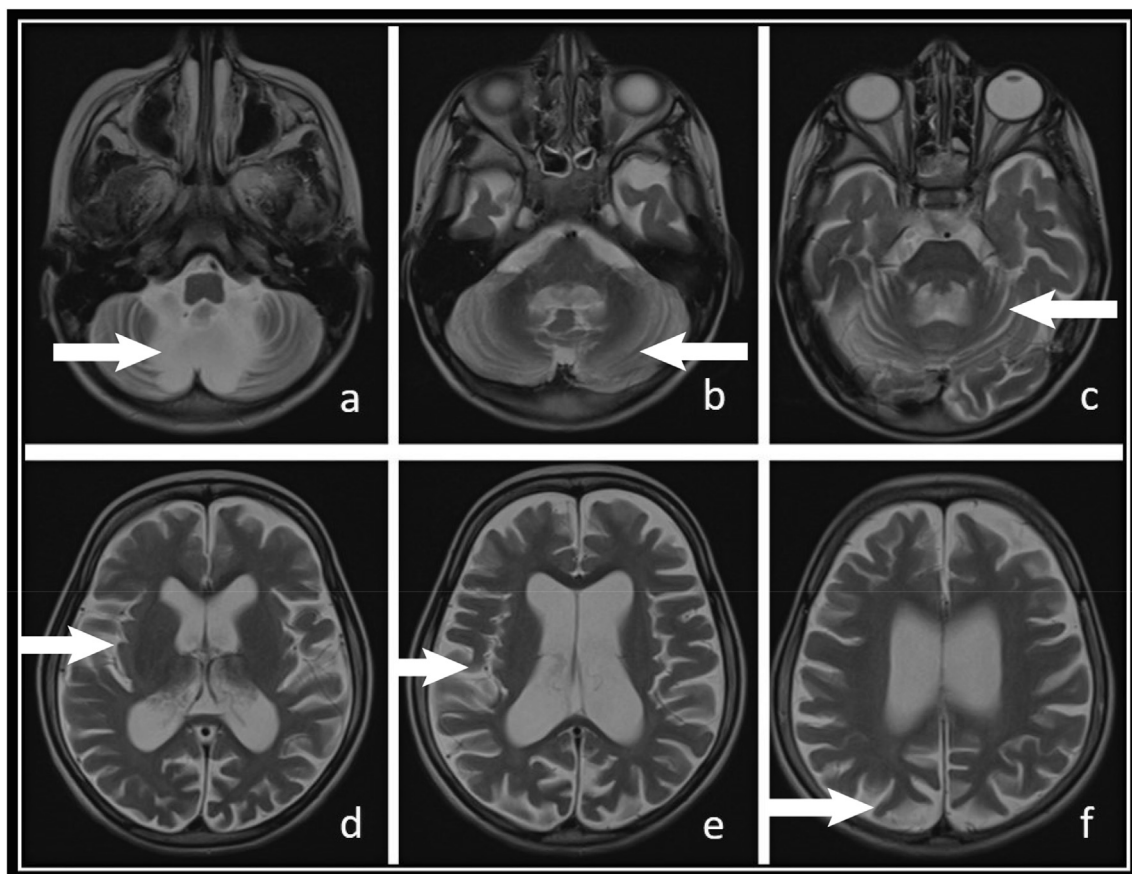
Patient 1 – T2-weighted axial sections from an MRI scan taken 2 years after the onset of symptoms. This scan reveals significant progression of cerebellar (a, b, c) and cerebral (d, e, f) atrophy compared with the scan taken 1 year earlier.
